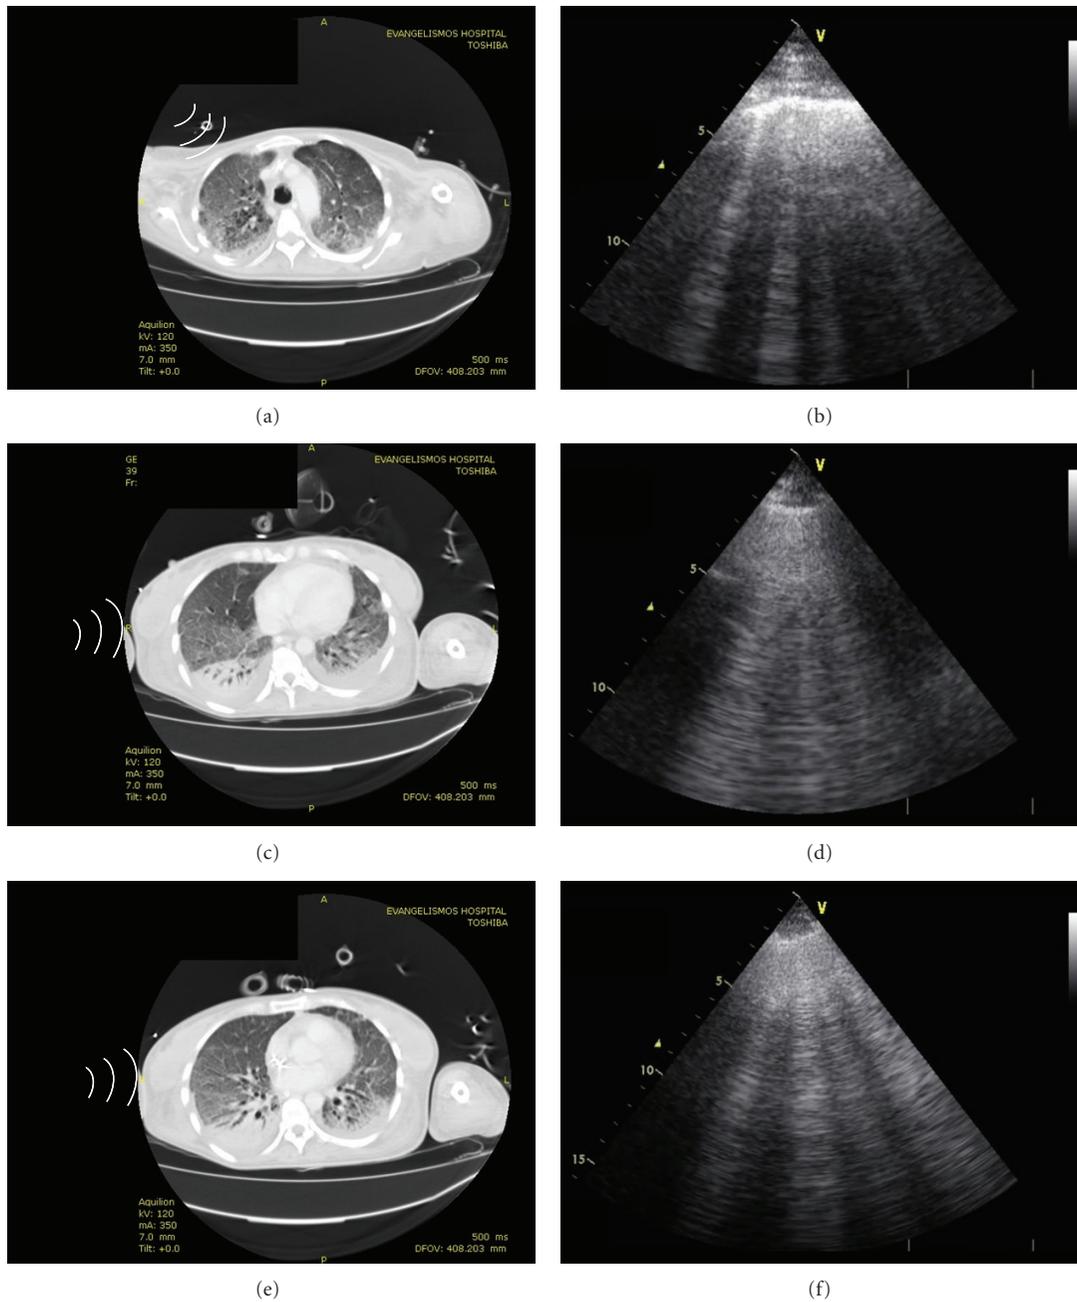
Computed tomography (CT) scans showing areas of “ground glass” opacification and bilateral-dependent areas of dense consolidation in a patient with acute respiratory distress syndrome (right panel). Lung ultrasound scans in the same patient depicting B-lines arising from the pleural line, confirming thus a pattern of diffuse alveolar-interstitial syndrome (left panel).
